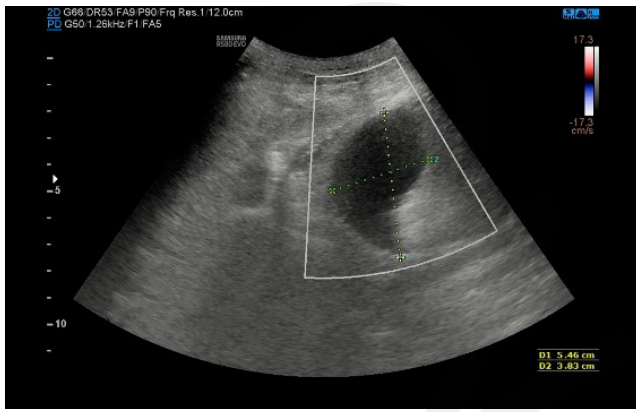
Ultrasound image of posterior compartment of thigh in axial (A) and sagittal (B) plane. Massive irregular free fluid – blood collection between muscles within the posterior compartment
